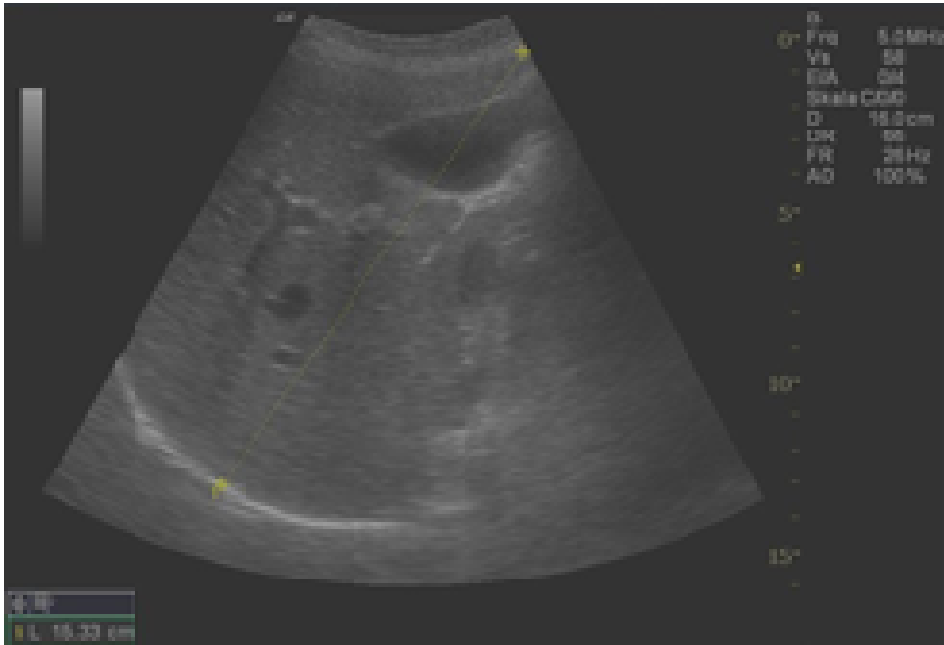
Ultrasound-picture of the liver in the right medioclavicular line. Hepatomegaly was defined as size above 155mm.
